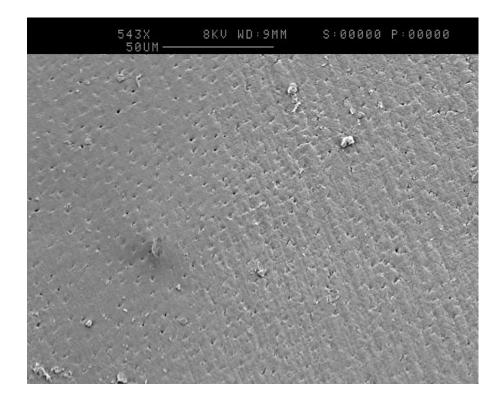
SEM image (500x magnification) to show Hülsmann score 2, in Group 7, treated ultrasonication in distilled water for 30 minutes.
